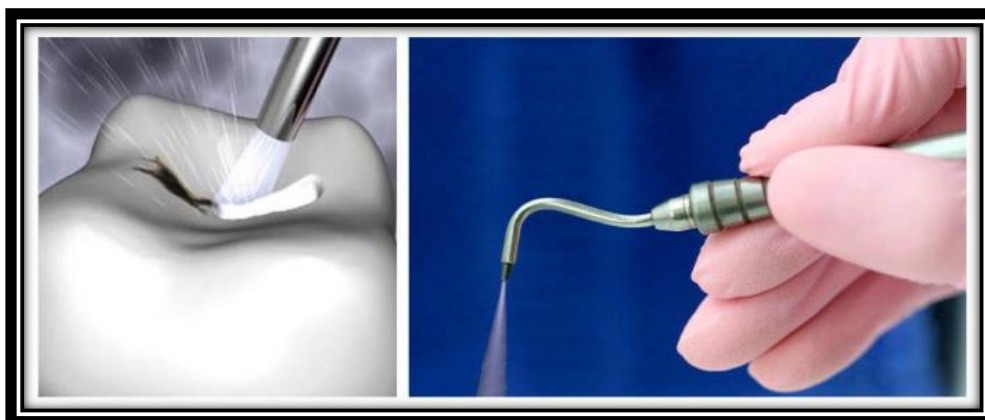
ultrasound caries detector.
